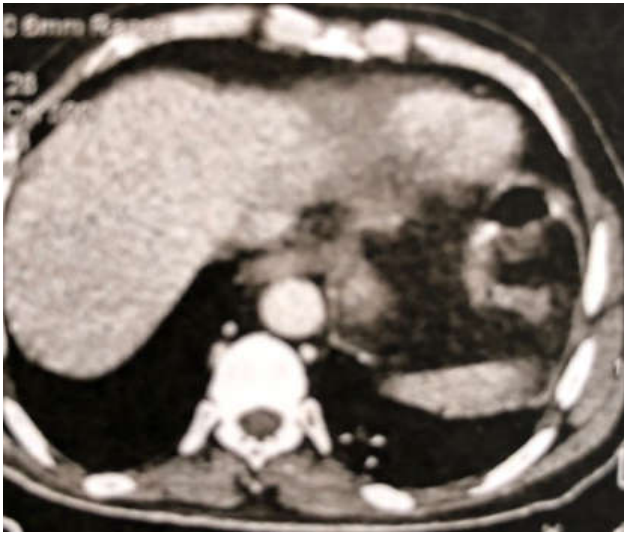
CT scan with pneumoperitoneum and poorly limited collection of the hiatal area
